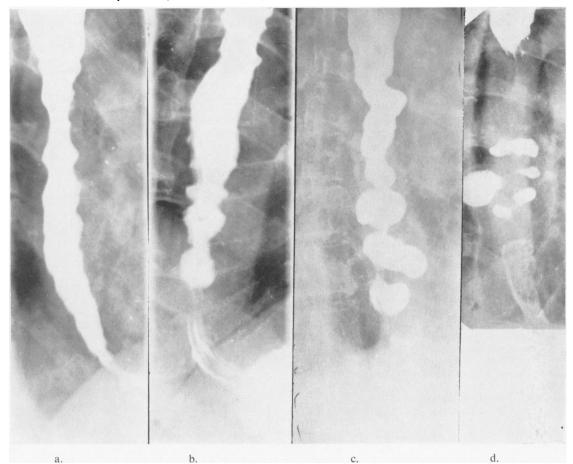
Demonstrations of the gamut of oesophageal radiographic appearances in symptomatic diffuse spasm.FIG. 1a (R.B.) Tertiary contractions or curlingFIG. 1c. (J.S.) Spastic pseudodiverticulosisFIG. 1b (F.C.) Segmental spasmFIG. 1d. (C.P.) Corkscrew oesophagus
